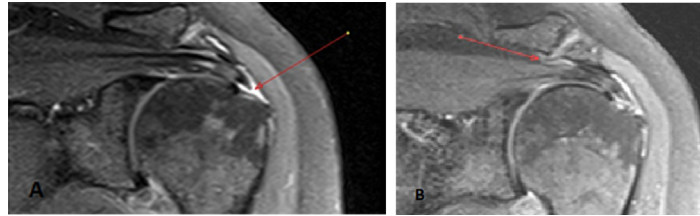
Left shoulder coronal oblique PD Fat Sat MR image (A) showing supraspinatus full thickness tear (arrow), image (B) shows acromioclavicular osteoarthritic osteophytes indenting the supraspinatus at the musculo-tendinous junction (arrow).
